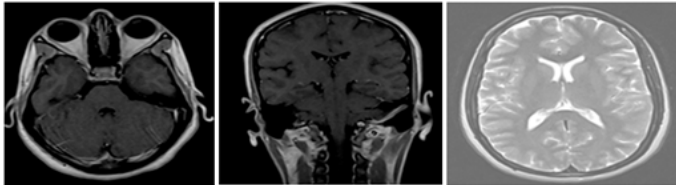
MRI of the patient, post contrast T1 Weight axial and coronal view and T2 axial view showing normal MRI study.
